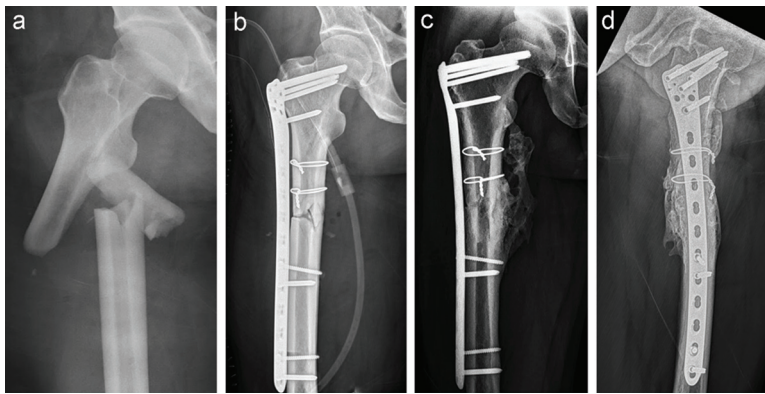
(a) The radiograph of a subtrochanteric fracture in a 28-year-old male patient who sustained a motor vehicle accident. (b) Immediate post-operative radiograph after treatment with reverse contralateral DF-LCP fixation. (c, d) Six-month post-operative radiographs demonstrate complete bone healing with callus formation.
